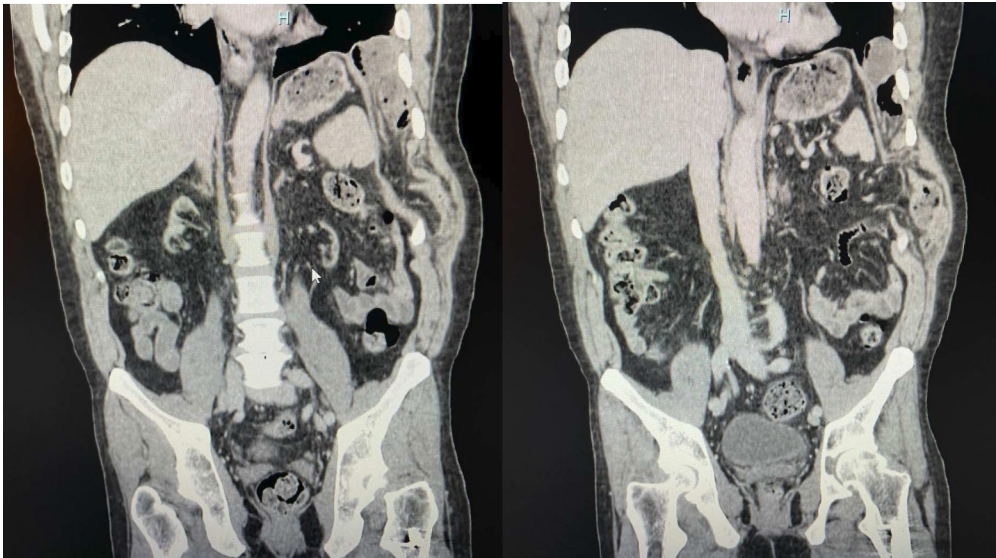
Coronal slices of admission CT of the abdomen/pelvis with intravenous contrast demonstrating an intercostal hernia in the ninth intercostal space containing small bowel.
